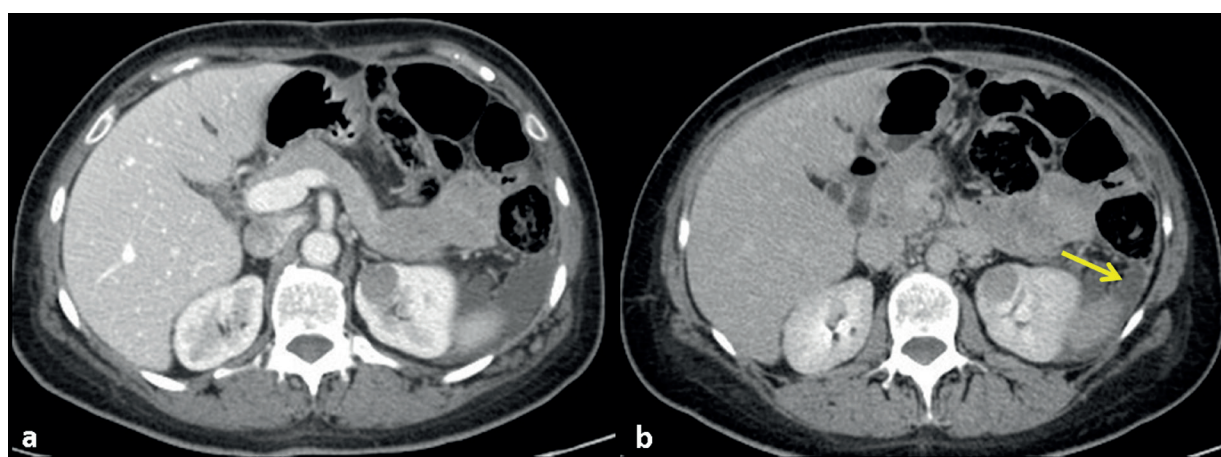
a-b. Axial CT images obtained in portal (a) and delayed (b) phases. A micronodular lesion was correctly detected by less-experienced reader only at reading session b and c, based on higher enhancement of lesion obtained in delayed phase image (arrow in b), as confirmed by SOR (micronodular pattern of carcinomatosis involving the left paracolic gutter). False negative case for SET A – True positive case for SET B and C.
